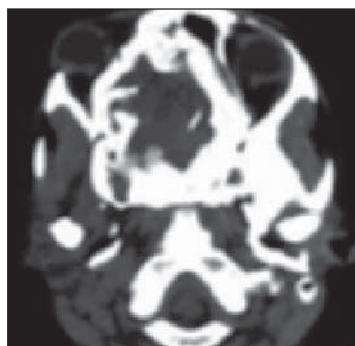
CT scan axial view
